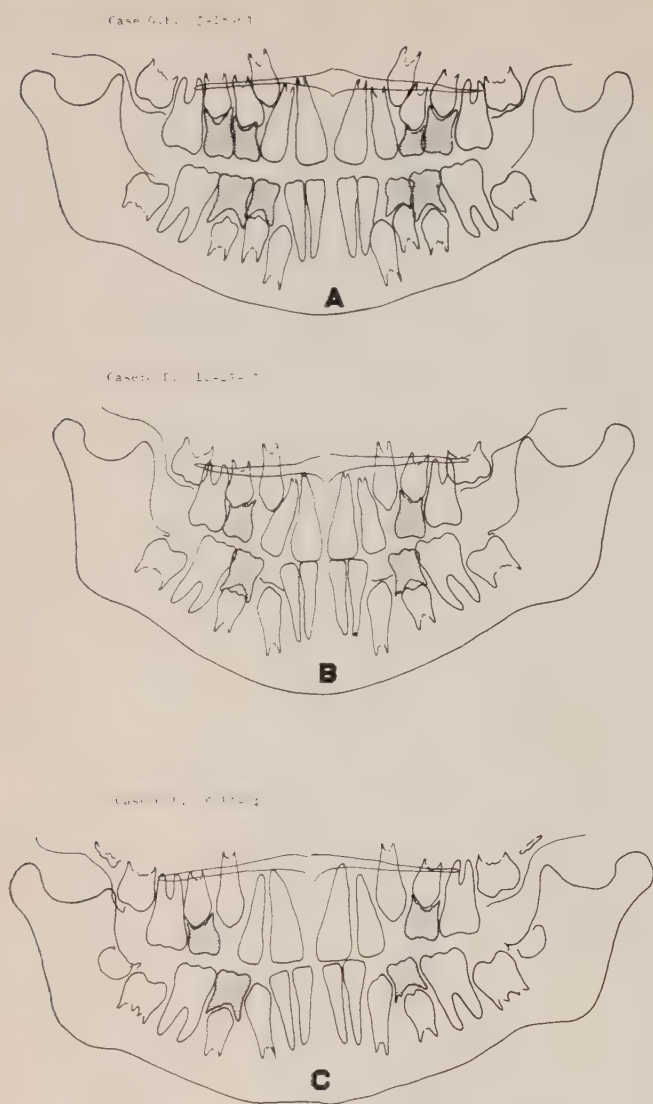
Same case as (D) in Figure 12. Tracings made at periodic intervals of panoramic radiographs taken to guide a pre-treatment serial extraction program. A, March 18, 1963. B, October 23, 1963. C, May 13, 1964.
